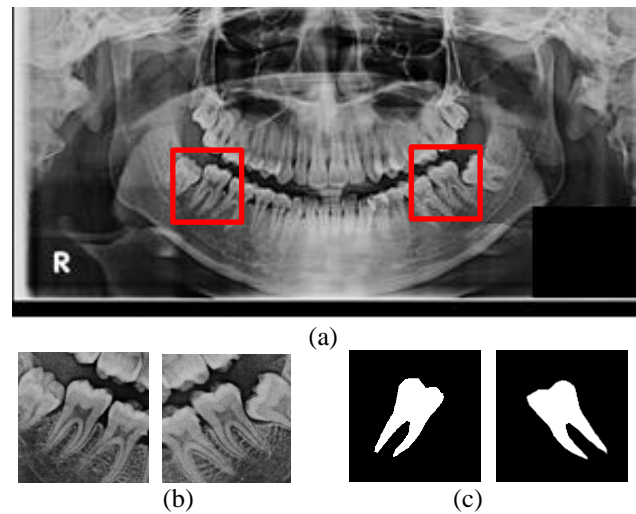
panoramic radiography image: (a) Panoramic radiography, (b) cropped mandible molar, right and left side, and (c) image masking
